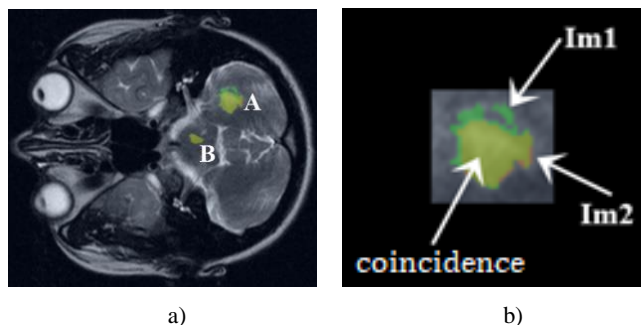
Jind metric demonstration: total image of MRI-section, with highlighted foci A and B (a); fragment of the MRI image with focus A (b)
